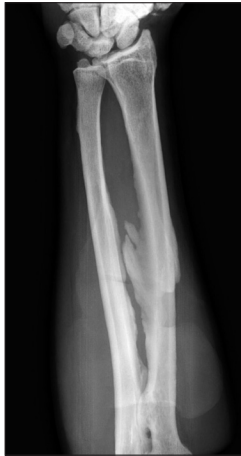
X-ray Left forearm AP reveals- Osteosclerosis with interosseous membrane calcification.
